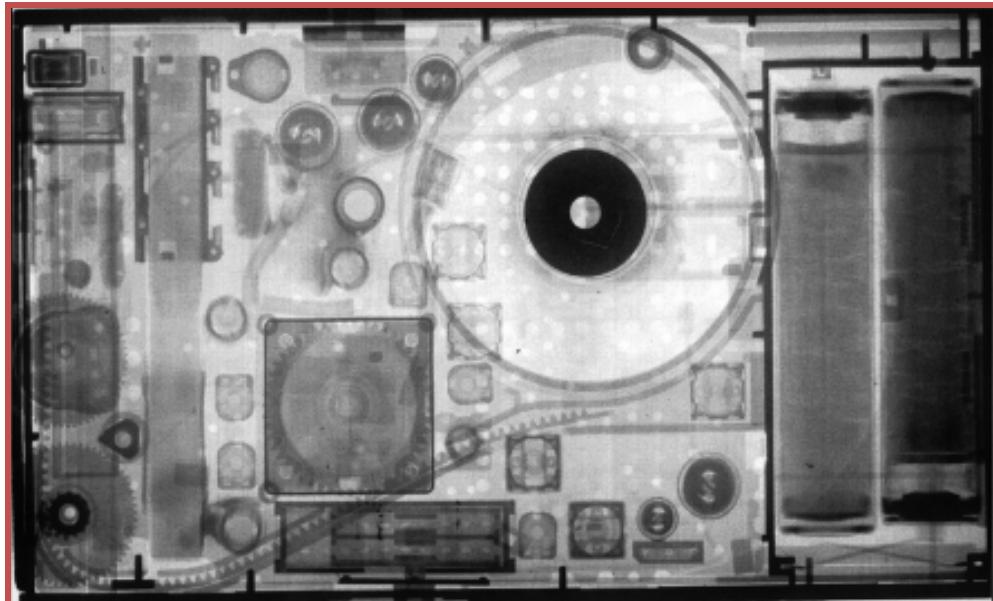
X-ray (top) and neutron (bottom) images of a miniature transistor radio. Images courtesy of Dr. Eberhard Lehmann taken using the ICON beamline, SINQ, Paul Scherrer Institut, Switzerland.
